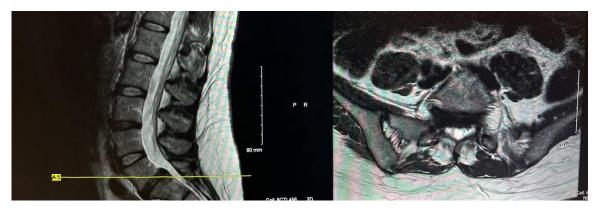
Pre-operative MRI of the Lumbar Spine at the L5-S1 level, demonstrating severe central canal stenosis and foraminal stenosis.
